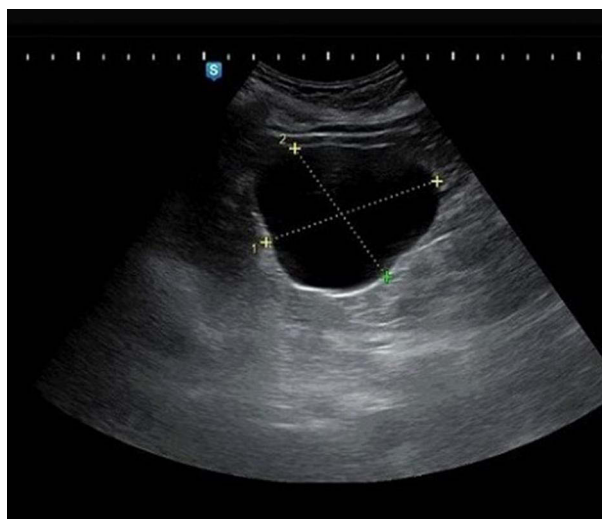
Renal ultrasonography of the left kidney. Gray-scale ultrasonography of the left kidney demonstrates a large, well-defined exophytic cystic lesion arising from the upper pole, measuring approximately 72×63 mm. The lesion appears anechoic with thin walls and posterior acoustic enhancement, consistent with a simple renal cyst. The surrounding renal parenchyma is preserved, with no evidence of hydronephrosis or calculi.
